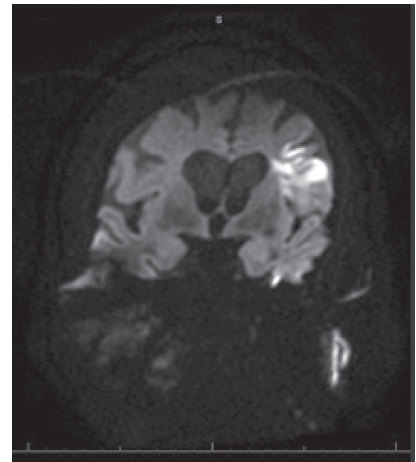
Coronal magnetic resonance imaging of the brain showing recent infarct.
